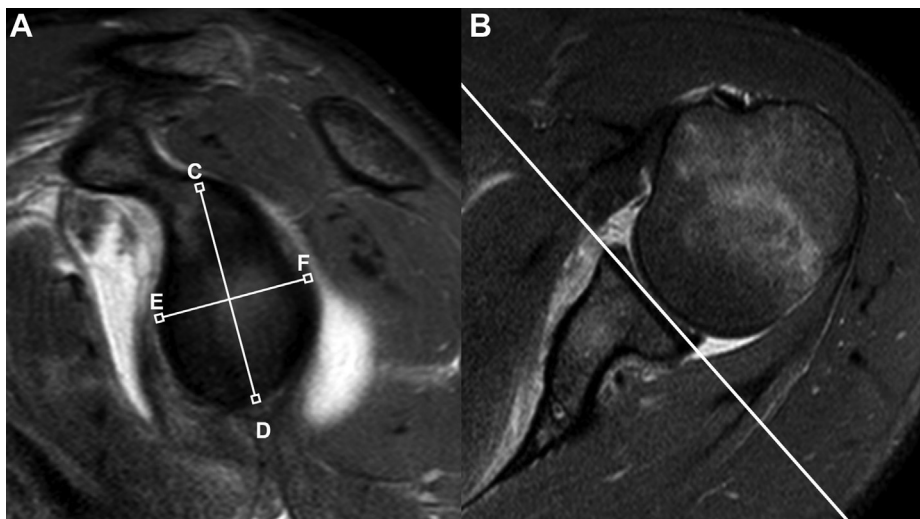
Shoulder T2 MRI sequences. (A) Sagittal plane of glena, glenoid height C-D, and glenoid width E-F. (B) Axial plane, with line represents the localization of the parasagittal plane image. The highest part and the widest part in the most lateral available parasagittal image of the glenoid are taken as reference to carry out the measurements. MRI, magnetic resonance imaging.
